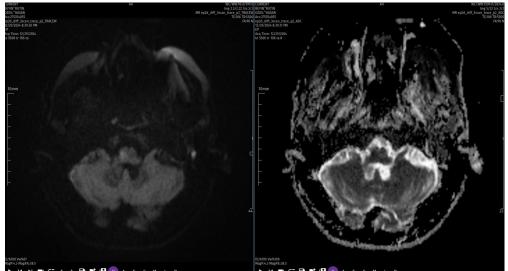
Diffusion MRI Image of the Case
